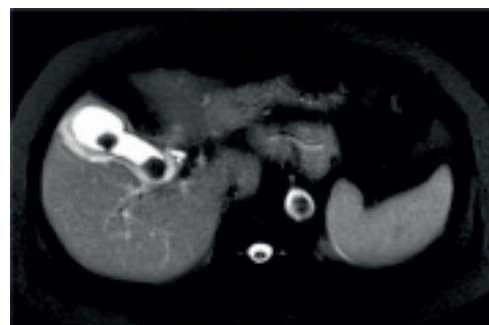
Axial T2W fat-suppressed MRI shows diffusely thickened GB wall with intraluminal calculi and complete pericholecystic adhesions with liver. Signs of pericholecystic edema & non-visualization of Calot's triangle are also noted.
